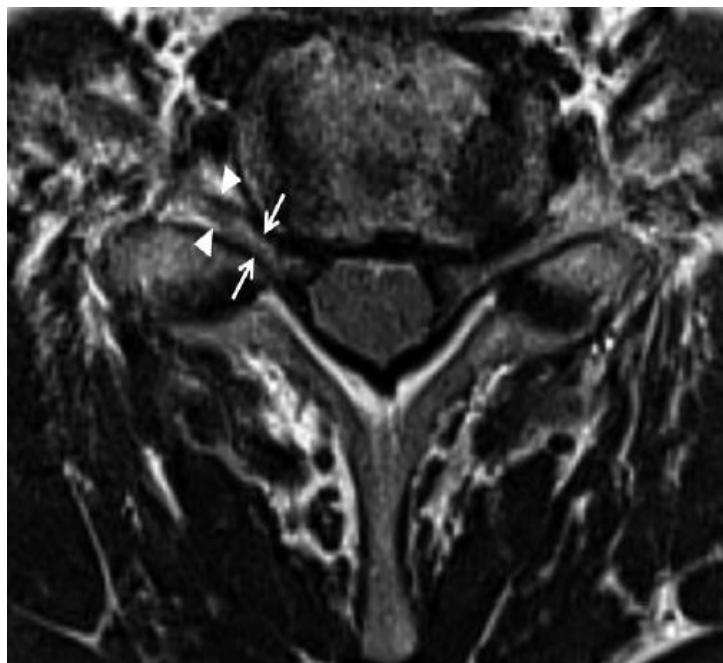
Axial T2 MRI showing compression of the cervical nerve root using the Kim grading system
